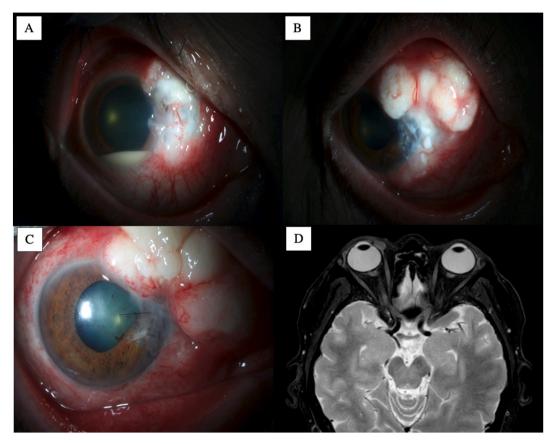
Slit Lamp and Magnetic Resonance Imaging of Sclerokeratouveitis and Conjunctival Squamous Cell Carcinoma. (A) A scleral infiltrate with keratitis and hypopyon in the right eye on initial presentation. (B) Post-operative month one after repair of limbal perforation demonstrating new scleral nodules (C) that grew into confluent leukoplakic lesions. (D) T2-MRI demonstrates a superonasal conjunctival lesion that extends into the medial rectus muscle insertion site.
